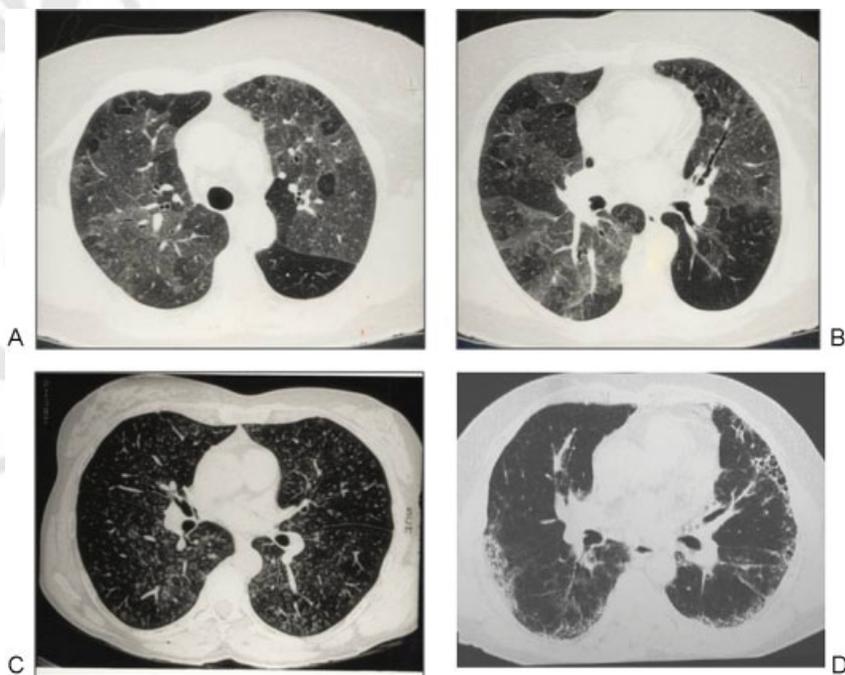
High-resolution chest computed tomography scans. (A and B) Mosaic pattern; (C) micronodular pattern; and (D) usual interstitial pneumonia pattern.
